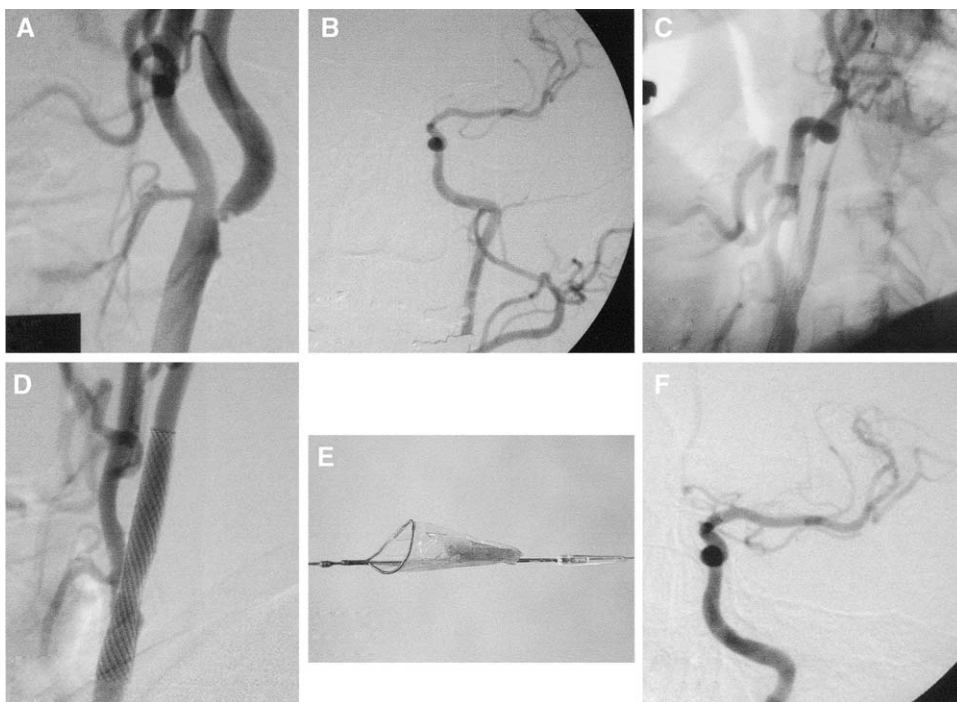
This 58-year-old man presented with stable angina. Preoperative carotid Doppler ultrasound imaging demonstrated increased systolic velocities in the right carotid artery (419 cm/s). (A) Cerebral angiogram demonstrating the presence of severe stenosis involving the origin of the right internal carotid artery (ICA). (B) Intracranial image, frontal view, revealing lack of filling of the anterior cerebral artery, which suggests a flow-limiting effect of the cervical lesion or hypoplastic A1 segment of the anterior cerebral artery. Right carotid angioplasty with stenting was performed using a combination of an EPI FilterWire (Boston Scientific, Natick, Massachusetts) and a Wallstent (Boston Scientific). (C) After the poststent deployment angioplasty was performed, slowing of filling of the right ICA was noticed. This finding was attributed to the presence of debris in the filter. (D) After filter retrieval, normal flow was re-established in the right ICA. (E) Inspection of the filter demonstrated the presence of a large piece of plaque. (F) Intracranial image after cervical revascularization demonstrated flow augmentation with filling of the anterior cerebral artery territory in spite of the presence of a hypoplastic A1 segment.
